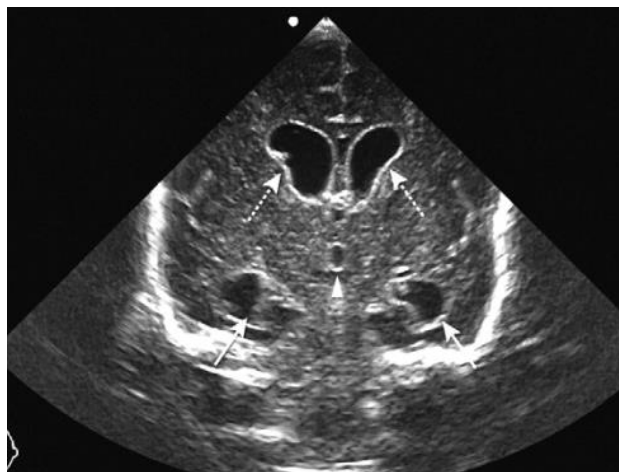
Coronal ultrasound scan in preterm infant with post-hemorrhagic ventricular dilatation, showing dilated frontal (dotted arrows) and temporal (arrows) horns of the lateral ventricles and third ventricle (arrow head). Also, Echogenicity lining the ventricles compatible with ventriculitis.
